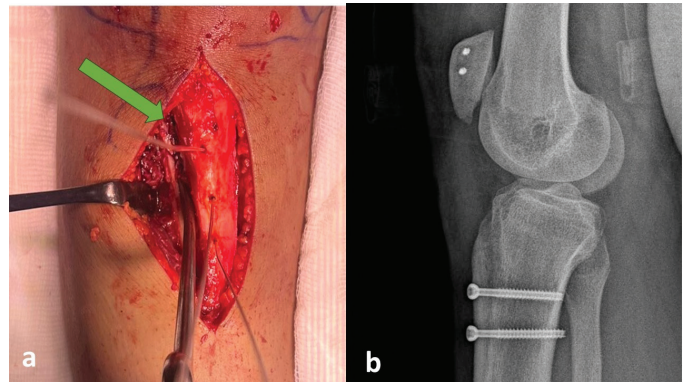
a) Medial and anterior transfer of the tibial tubercle after osteotomy (green arrow) and fixation with guide wires. b) Radiographic image of the tibial tubercle osteotomy line in the second postoperative year
